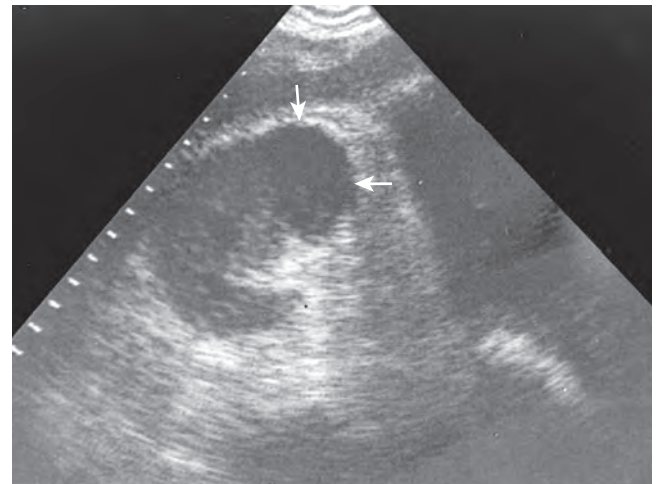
Acute renal abscess. Transverse ultrasound image of the right kidney demonstrates a poorly margined rounded focal hypoechoic mass (arrows) in the anterior portion of the kidney.
